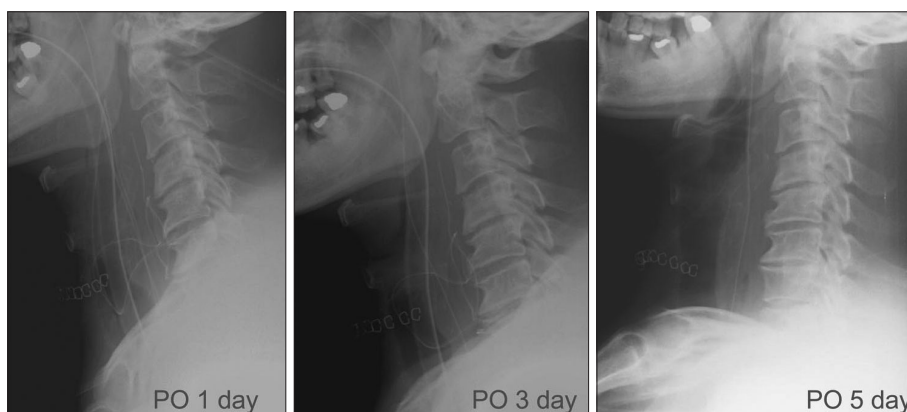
Lateral X-ray images after surgery. A gradual decrease in the widening of the prevertebral space is seen. At the fifth postoperative day, extubation was possible.
